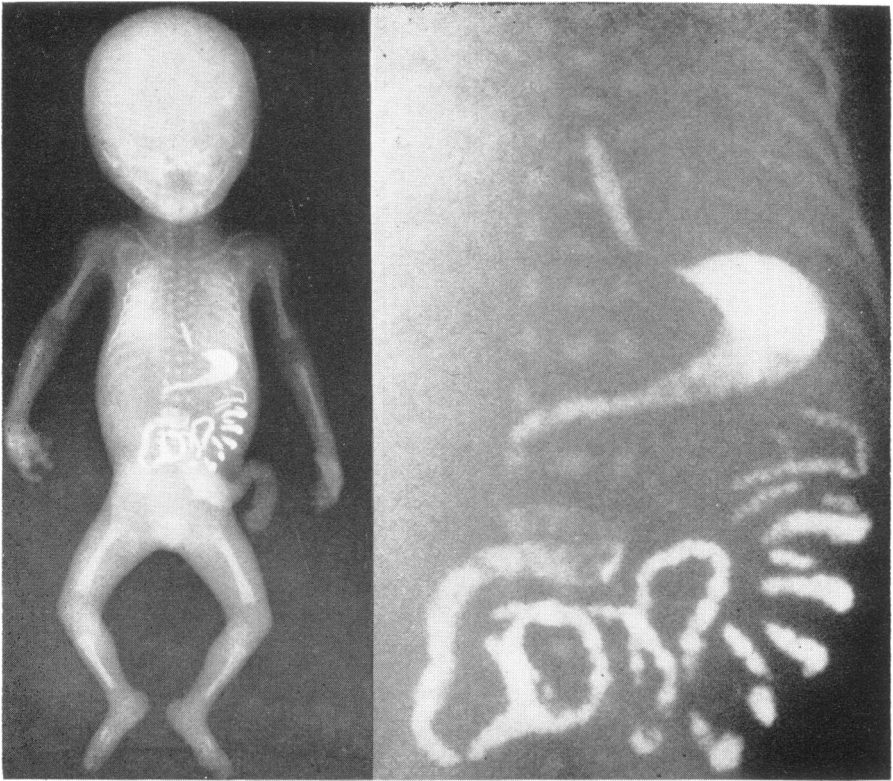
Phrenic ampulla in a 3.5-month-old fetus; author's radiograph of a preparation by Dr. Edith Potter.
